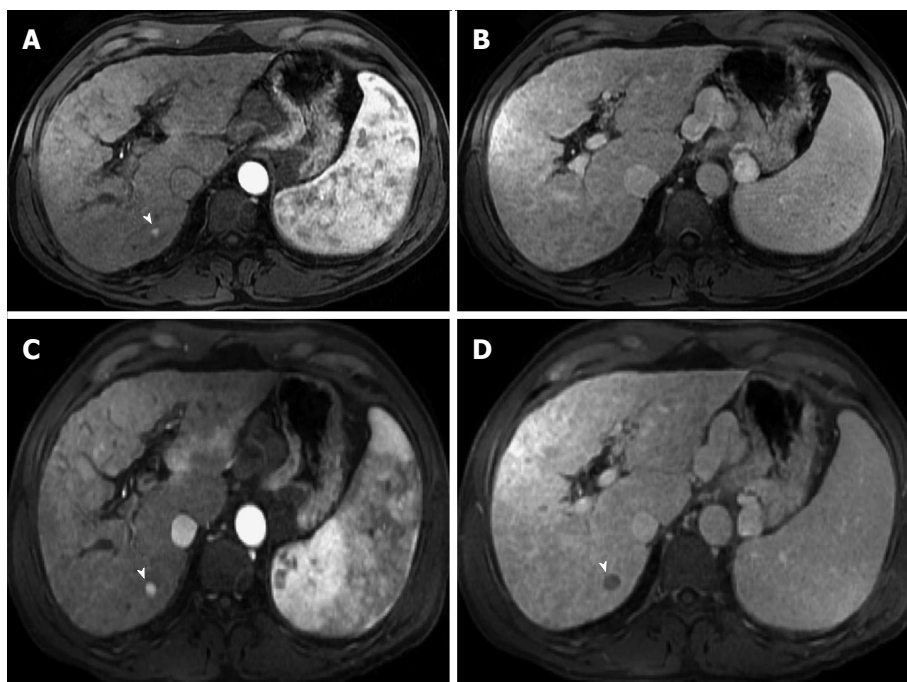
Dysplastic nodule progressing into an hepatocellular carcinoma. Post-contrast fat-suppressed 3D-GRE T1-weighted images during the late hepatic arterial (A and C) and delayed phases (B and D). There is a small right hepatic lobe nodule, which demonstrates increased arterial enhancement (arrowhead, A) and fades out on the delayed images (B) on the initial examination. On the 4-month follow-up study, there is evidence of interval growth (arrowhead, C, D) and development of clear delayed washout (arrowhead, D) both of which are signs of progression into HCC. HCC: Hepatocellular carcinoma; GRE: Gradient recalled echo.
